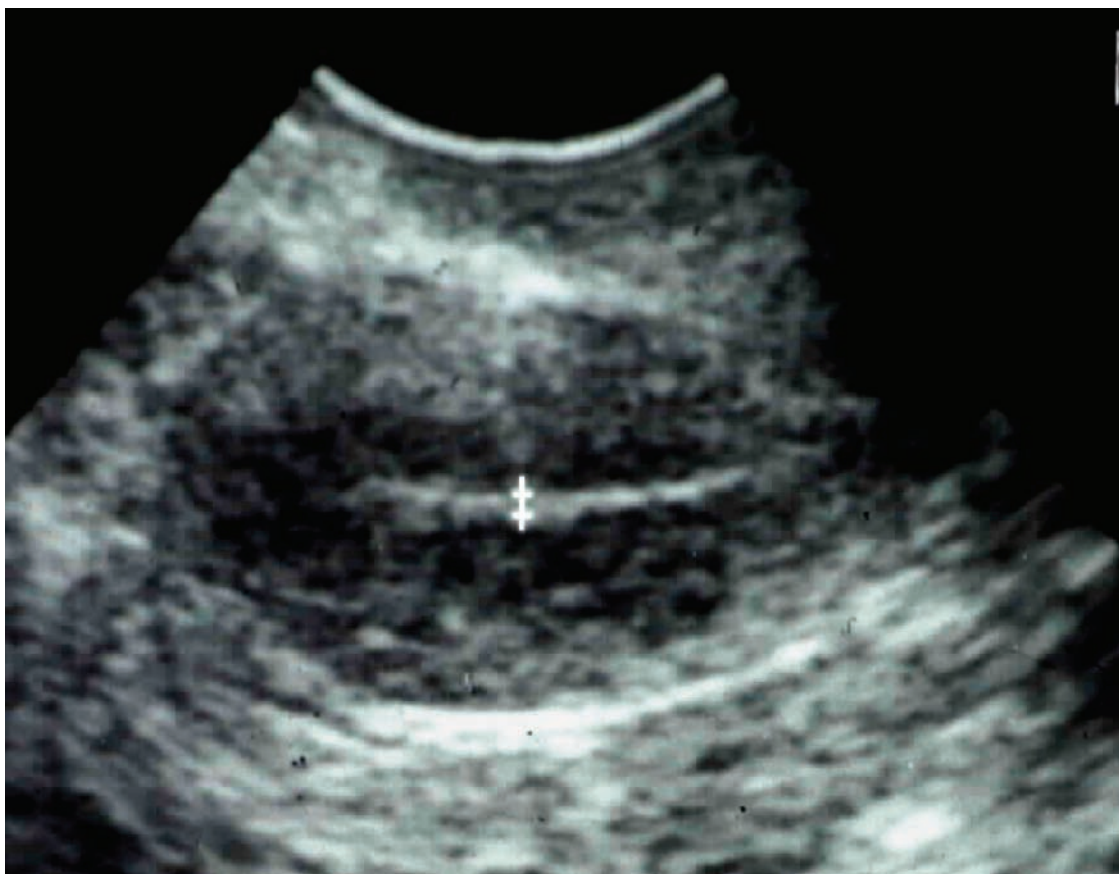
Transvaginal ultrasound of the uterus in the longitudinal plane. *Cursors*, endometrium (in mm) at the thickest point between the two basal layers on the anterior and posterior uterine walls.
